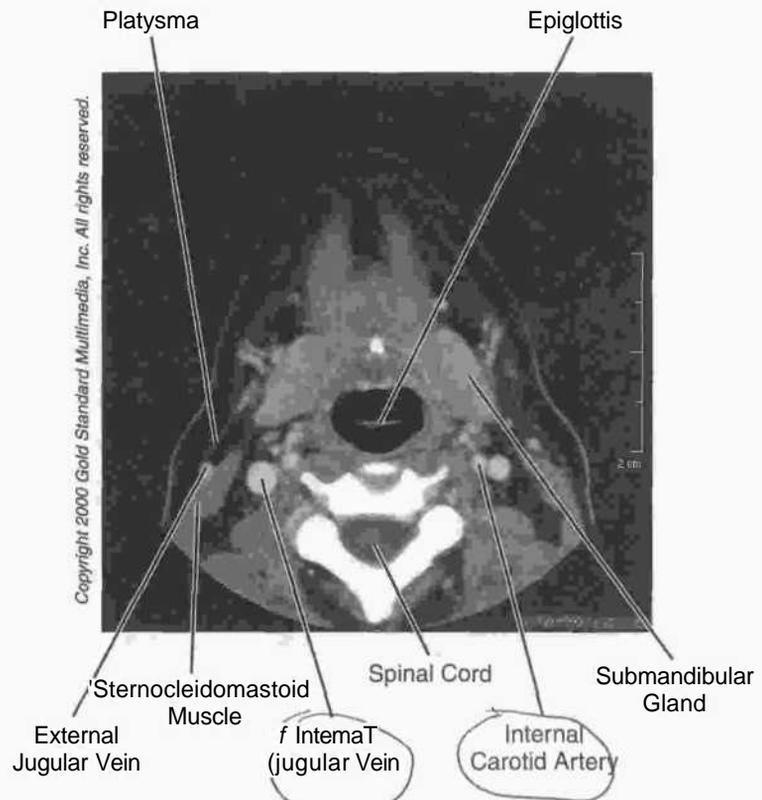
Head and Neck: CT, Neck at C₂ vertebra
